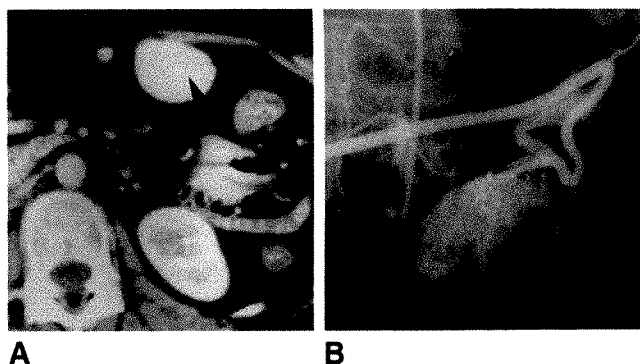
Contrast-enhanced CT scan (A) and selective arteriogram of right gastroepiploic artery (B) show a vascular mass in greater omentum (arrow) in a woman with Castleman disease.
